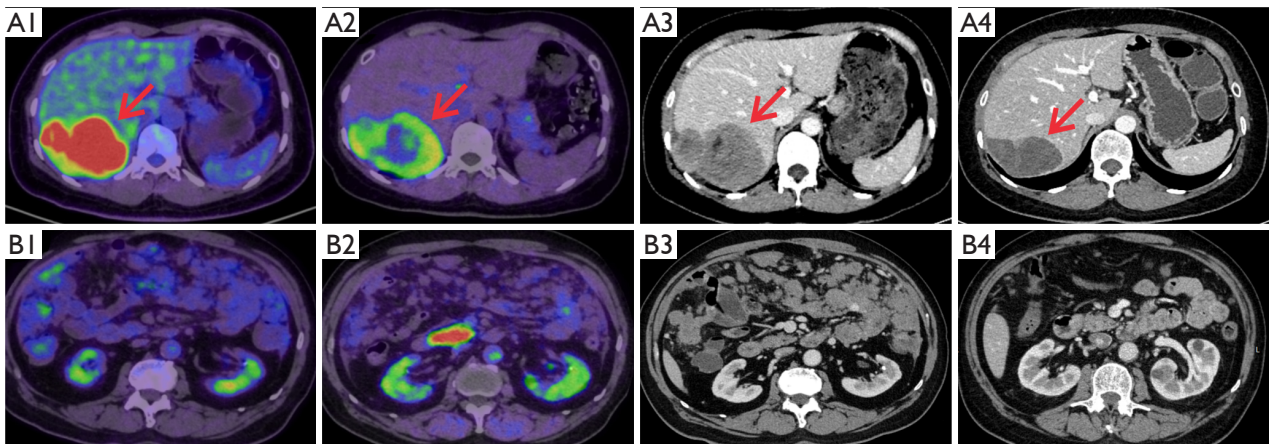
Two patients with recurrent or metastatic GISTs using a response prediction model based on $[^{18}F]$ FAPI-42 and $[^{18}F]$ FDG PET/CT parameters. (A1,B1) The fusion image of baseline $[^{18}F]$ FDG PET/CT; (A2,B3) the fusion image of baseline $[^{18}F]$ FAPI-42 PET/CT; (A3,B3) baseline contrast-enhanced CT; (A4,B4) the contrast-enhanced CT after six-month of new targeted therapy. (A1-A4) A case who had liver metastasis following the resection of small intestinal GIST. (A1,A2) (red arrows) show that FDG and FAPI-avid in liver metastases significantly increased; the probability of progression was less than 1.0% according to the nomogram. (A3,A4) Red arrows show that the longest diameter of liver metastases shortened by about 16.0% after six months of targeted therapy (SD, non-progression). (B1-B4) A case that developed diffuse peritoneal metastases following the resection of GIST. (B1,B2) Diffuse multiple peritoneal metastases with focal areas of slightly increased uptake on both FDG and FAPI PET/CT scans; the probability of progression was less than 10%, according to the nomogram. (B3,B4) The number of metastatic nodules on the peritoneum was markedly reduced after six months of targeted therapy (PR, non-progression). GISTs, gastrointestinal stromal tumors; $[^{18}F]$ FAPI-42, $[^{18}F]$ -fibroblast activation protein inhibitor-42; $[^{18}F]$ FDG, $[^{18}F]$ -fluorodeoxyglucose; PET/CT, positron emission tomography/computed tomography; CT, computed tomography; SD, stable disease; PR, partial response.
